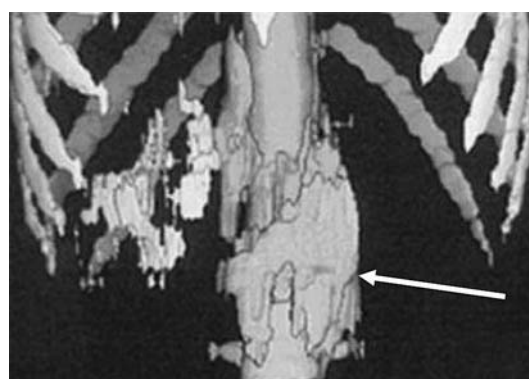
A 3-D CT reconstruction image shows that ethanol (mixed with high density contrast material) diffuses well pre- and paravertebrally (*arrow*).
